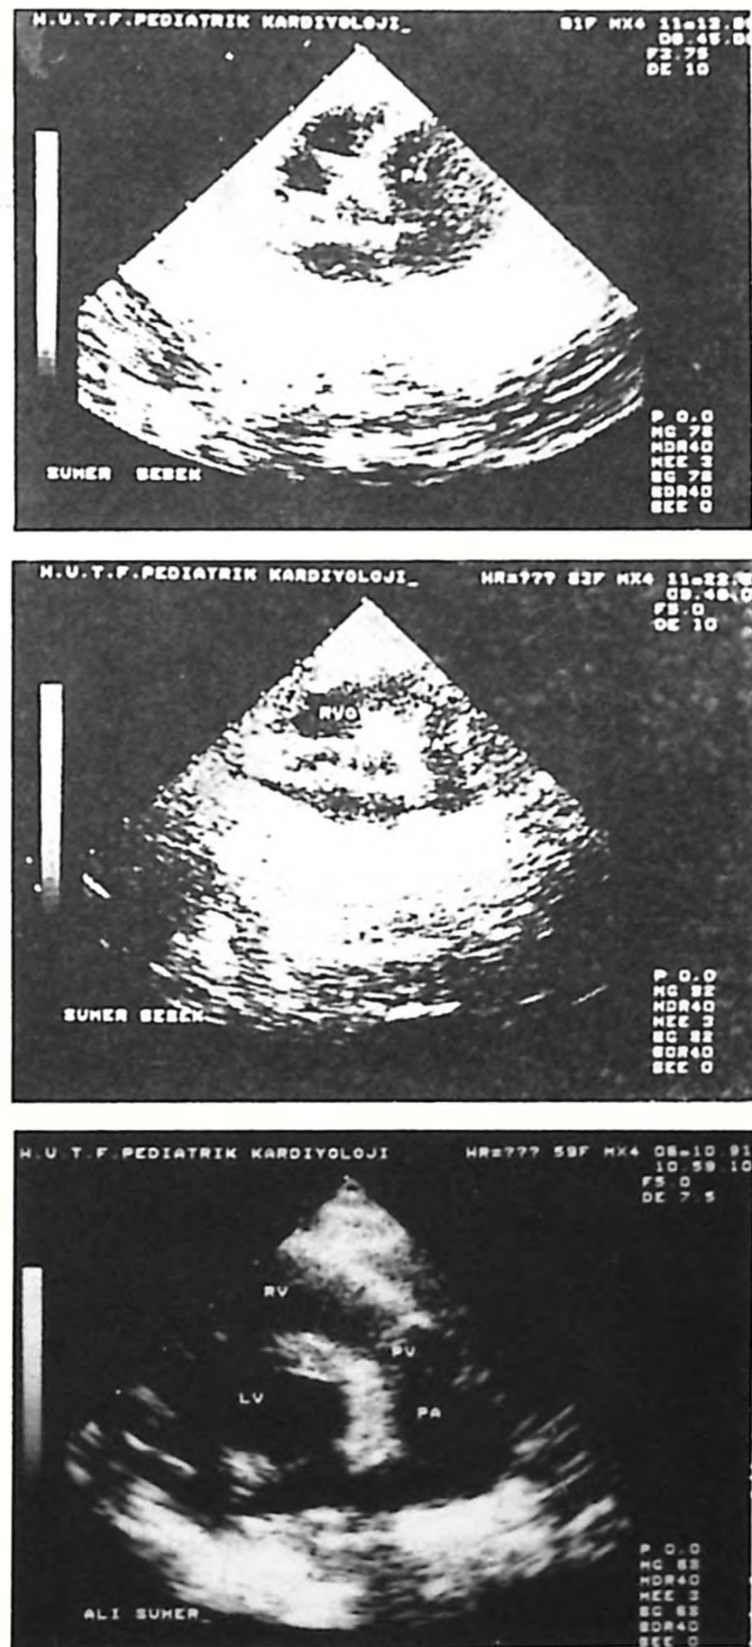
Two-dimensional echocardiography (a) preoperatively showing no pulmonary valves and 20 mm main pulmonary artery, and (b) post-operatively on the sixth day showing the pulmonary artery 9 mm in diameter, and (c) after one year of follow-up showing normal pulmonary artery. (AO: Aorta, PA: Pulmonary artery, RV: Right ventricle, LV: Left ventricle, RVOT: Right ventricular outflow tract PV: Pulmonary valve annulus).
